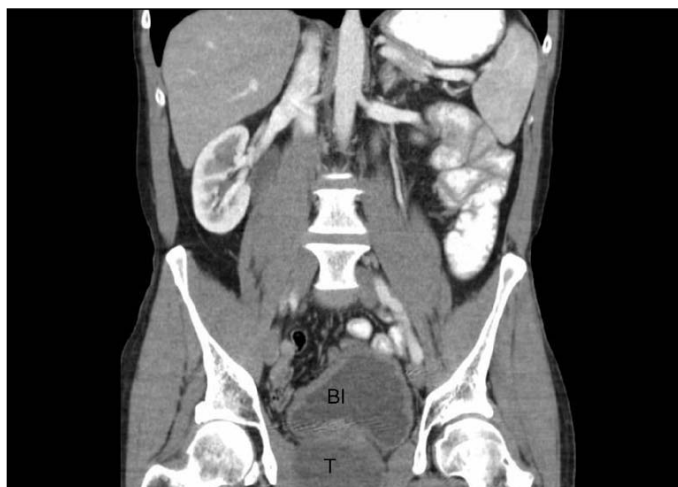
A coronal computed tomography scan showing recurrence of the tumour (T) inferior to the bladder (BI).
